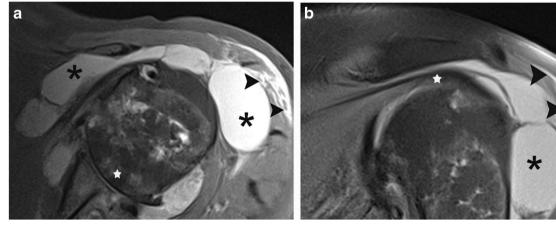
Images from an 89-year-old woman with no history of recent trauma and no rotator cuff tear. a Axial T2 BLADE fat-suppressed MR image demonstrates large subacromial-subdeltoid bursitis (asterisks), a full-thickness deltoid tear with retracted fibrils (arrowheads), and advanced glenohmeral osteoarthritis with cystic changes in the humeral
